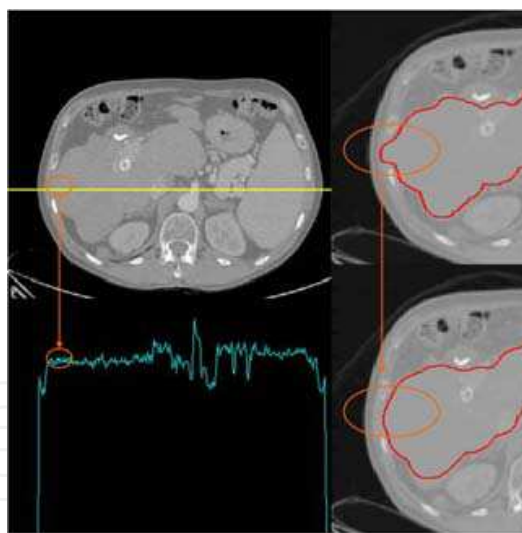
On the left*: transverse slice of an abdominal CT image and its profile of intensities along the yellow line showing the difficulty of establishing an intensity threshold between liver and adjacent intercostal muscles. *On the right*: active contour growing based on a classical gradient dependent definition (*above*) and the improvement introduced by the proposed method that avoids the contour to overflow among the intercostal space (*below*).
